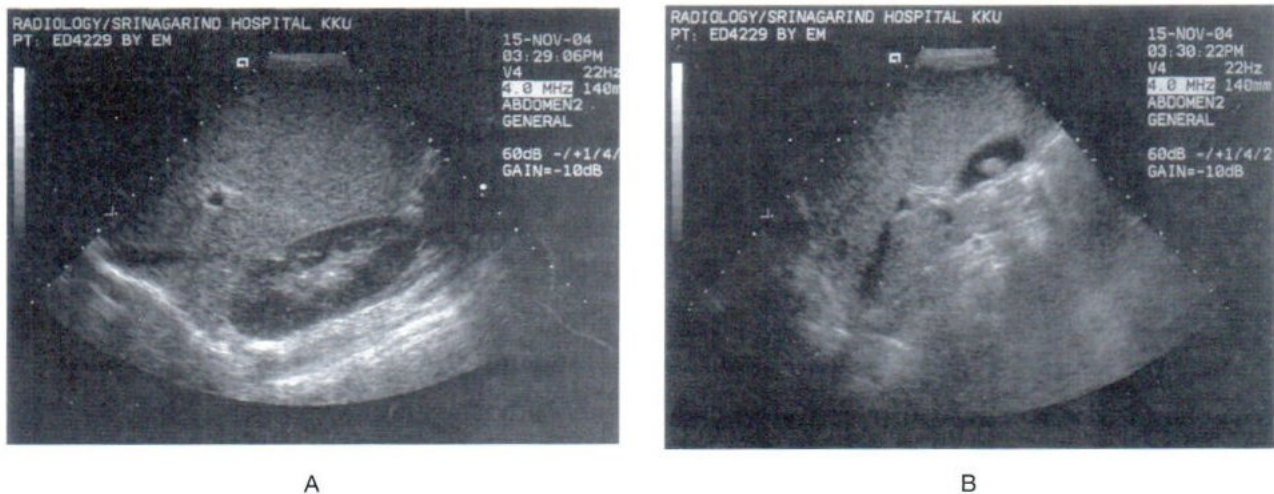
Ultrasonography (US) of a typical case of thalassemia. A) US shows diffusely and homogeneously increased liver parenchyma. B) US shows a gallstone.
